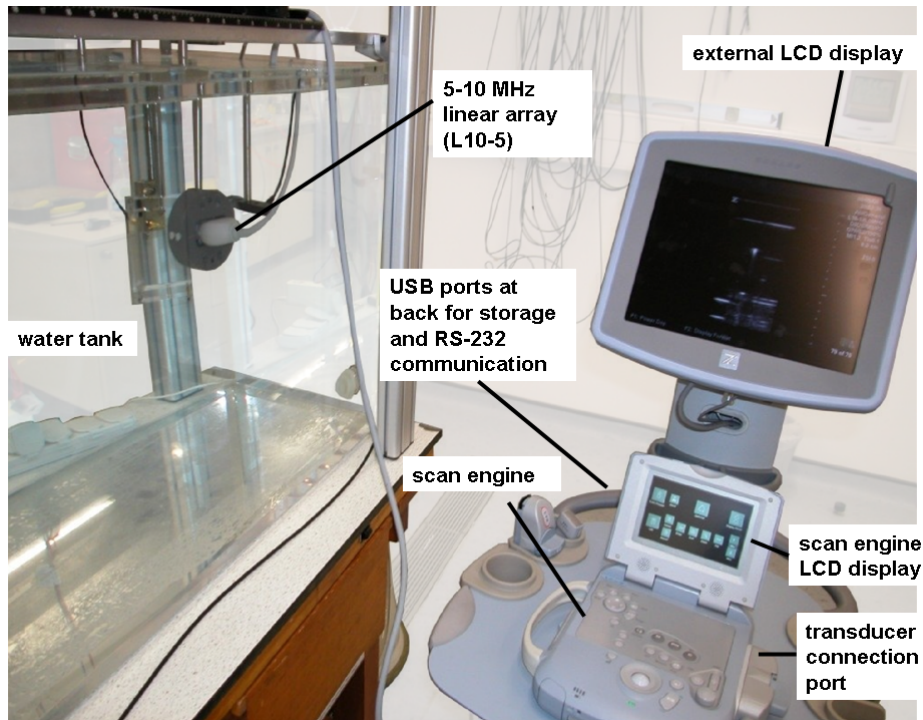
The z.one ultrasound engine from Zonare. The 5-10 MHz linear array is connected to the scan engine via the transducer connection port. Conventional B-mode images can be watched and reviewed using the external LCD display. Using two USB ports to the rear of the engine, communication with the scan engine with a serial interface is possible, as well as transfer of data to a USB storage device.
